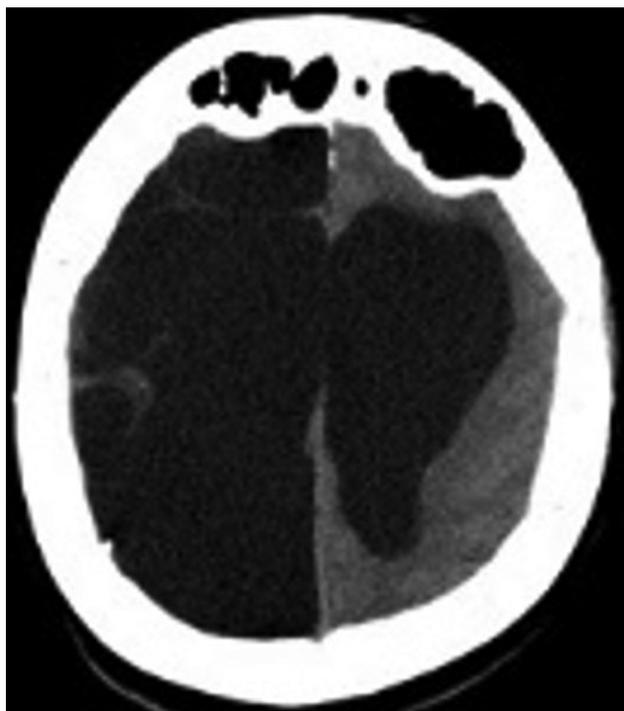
Cranial computed tomography (CT) showing supratentorial ventriculomegaly
